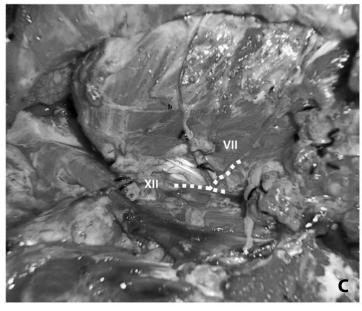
T2-weighted Magnetic Resonance Images showing the 5 cm heterogeneously enhancing lobulated mass centered within the deep lobe of the left parotid gland A. Extending to the left mastoid with facial nerve involvement B. Arrowhead.
